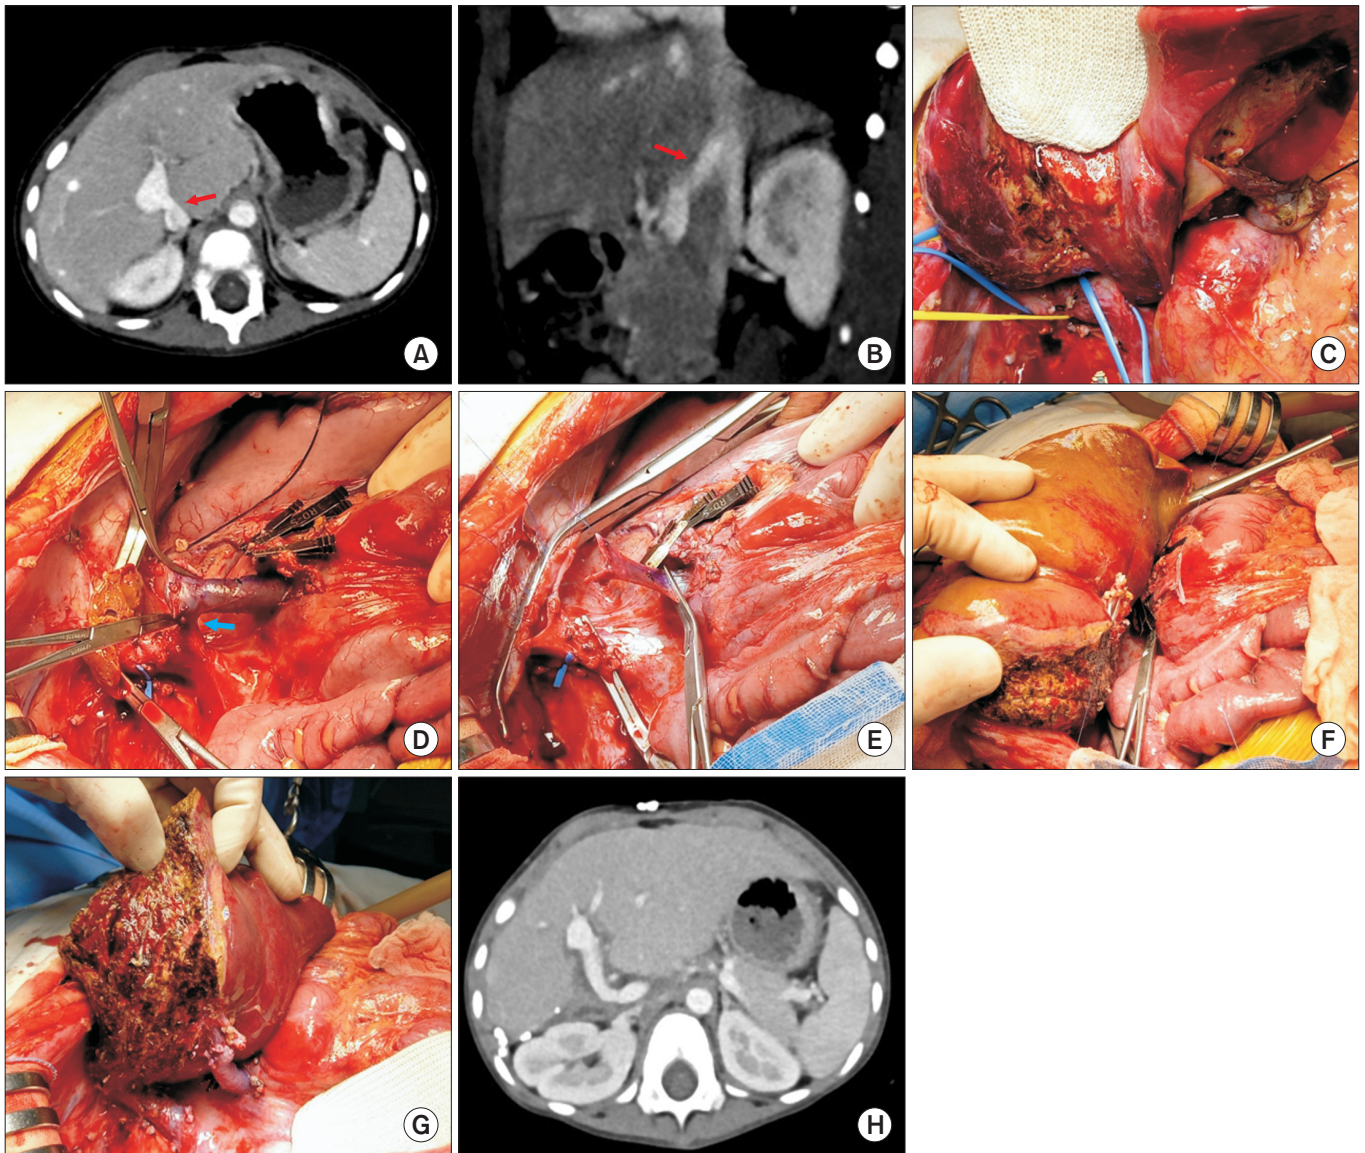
Image summary of living donor liver transplantation case 1. (A, B) Pretransplant computed tomography (CT) demonstrated normal extrahepatic portal vein anatomy, but a large portocaval shunt through the inferior right hepatic vein (arrows) was identified. (C) The enlarged inferior right hepatic vein was identified and encircled. (D) After removal of the native liver, the communicating inferior right hepatic vein was clamped and ligated. (E) The right and left portal vein stumps were opened to create a branch patch. (F) The recipient portal vein branch patch was anastomosed to the graft portal vein using 6-0 polydioxanone sutures. (G) After graft reperfusion, reperfusion status appeared normal. (H) Posttransplant CT obtained 2 weeks later showed that the graft portal vein was well perfused without evidence of stenosis. Reproduced from Namgoong et al. *Ann Liver Transplant* 2022;2:144–50. [6]
